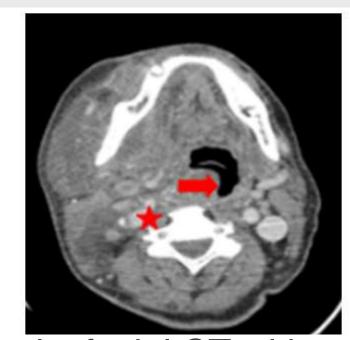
Axial cervicofacial CT with contrast injection:
